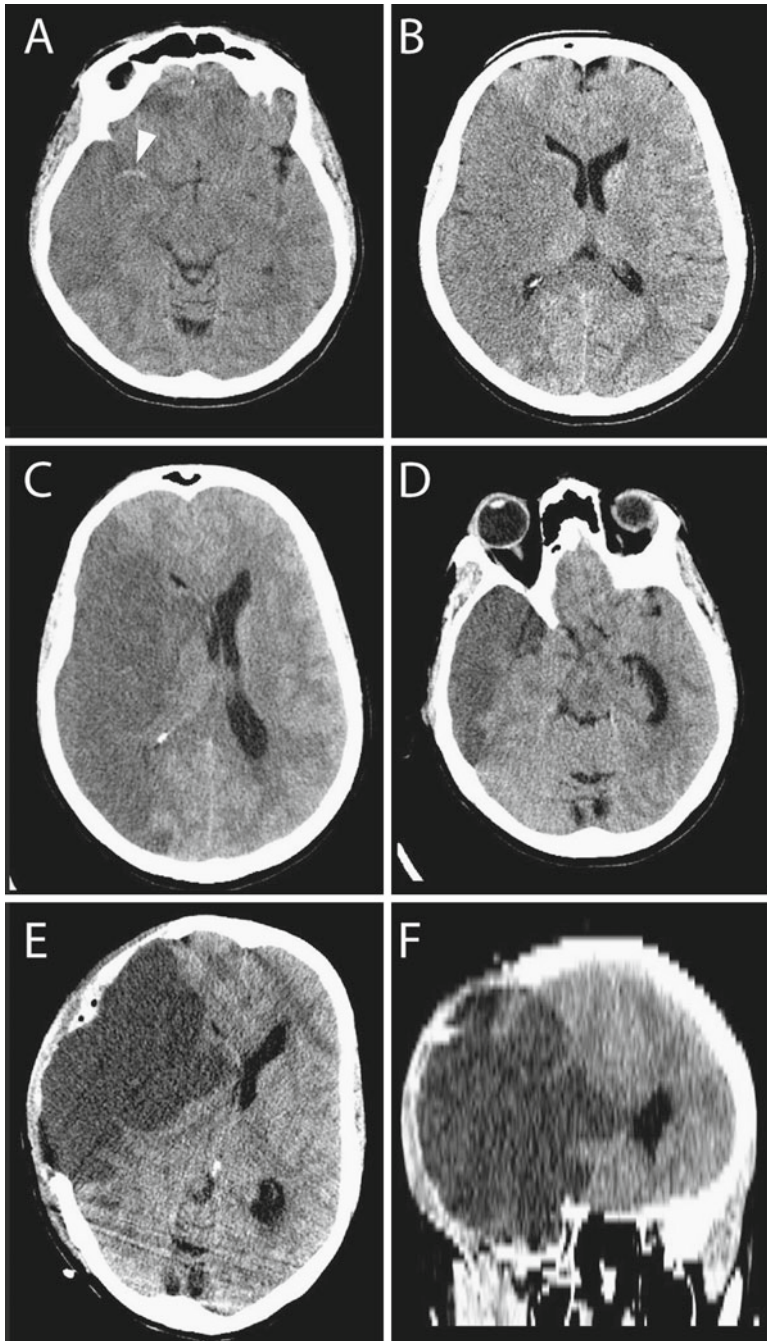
Decompressive craniectomy for malignant MCA stroke. This 48-year-old female experienced left hemiparesis following a cardiac procedure on cardiorespiratory bypass. (a) A hyperdense right MCA sign was observed (*arrow*) with MCA stroke. (b) The entire right MCA distribution was involved with diffuse hypodensity. The next day the patient had an acute loss of consciousness with a Cushing's response and dilated right pupil. (c, d) Urgent CT scan revealed malignant edema with midline shift (c) and uncal herniation (d). (e, f) Emergent decompressive craniectomy, subtemporal decompression, and duroplasty were undertaken to allow external herniation of edematous brain
